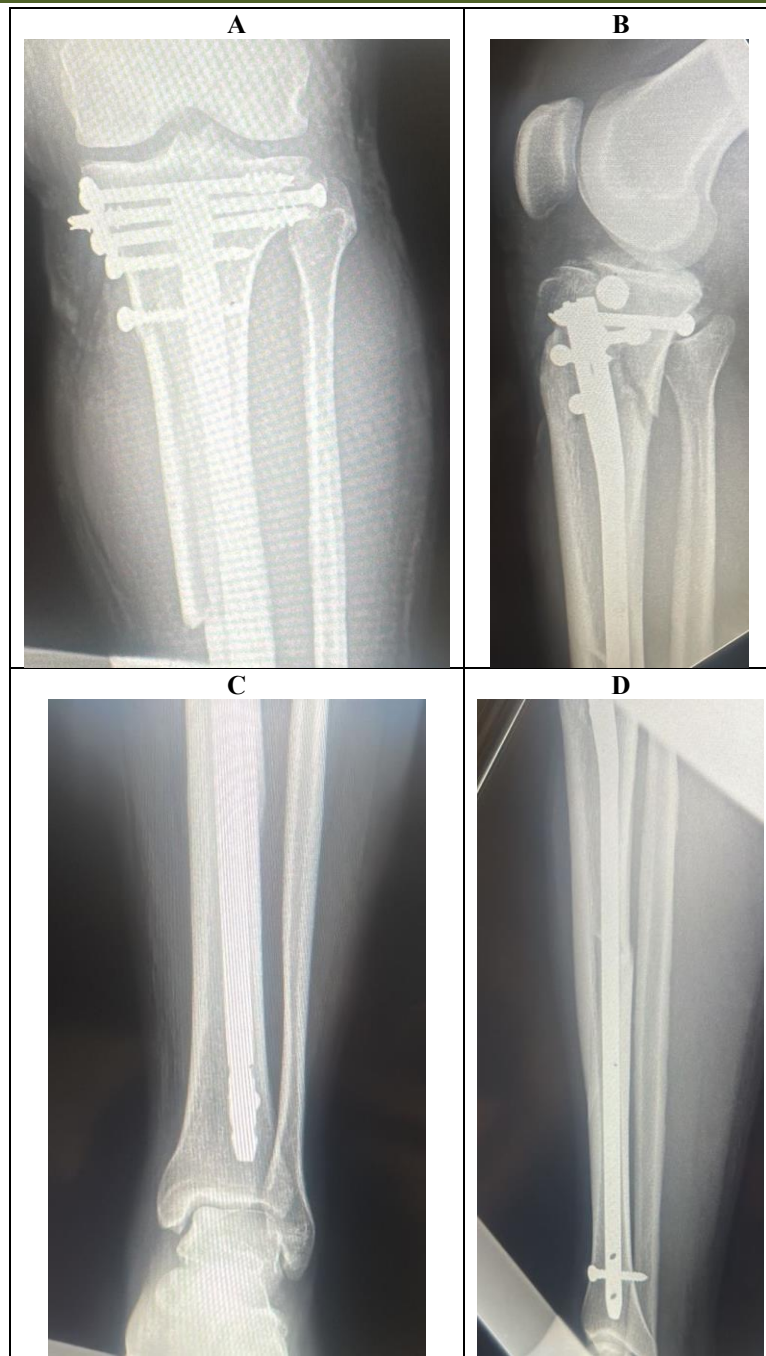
Immediate postoperative radiographs. (A-B) Anteroposterior and lateral views of the proximal tibia showing independent plateau screws, the tibial nail and the proximal interlocking screws. (C-D) Distal segment and distal locking. Overall alignment was restored without immediate secondary displacement
